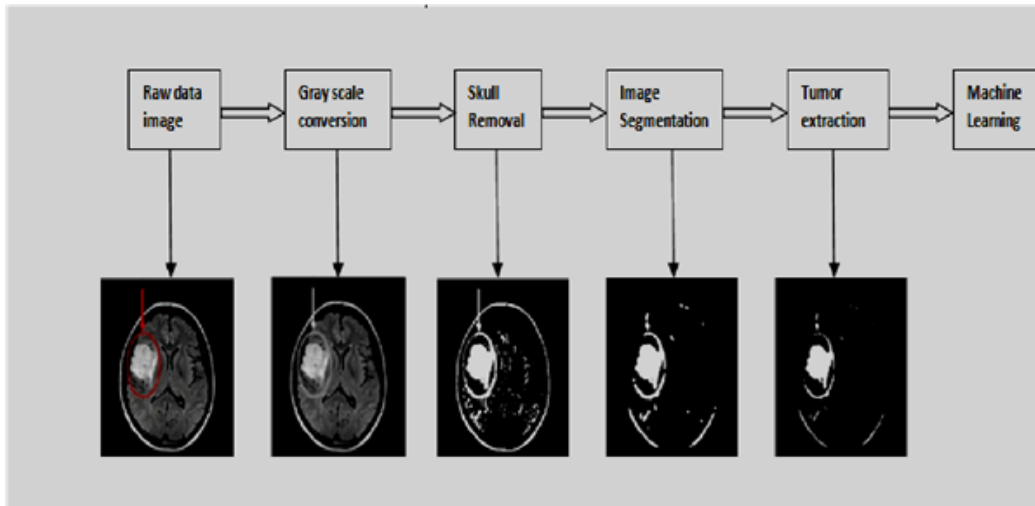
Preprocessing steps in one brain tumor MRI image
